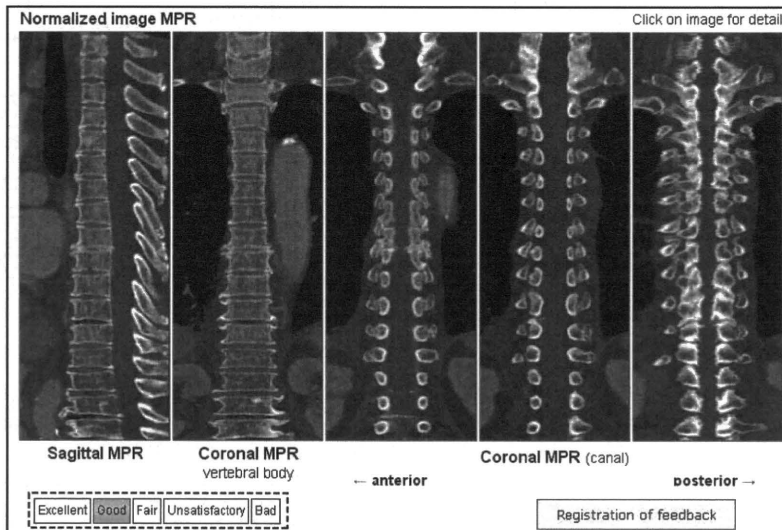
Result of virtual straightening of spine in whole-body CT images with feedback interface for entering visual score (dashed box).
